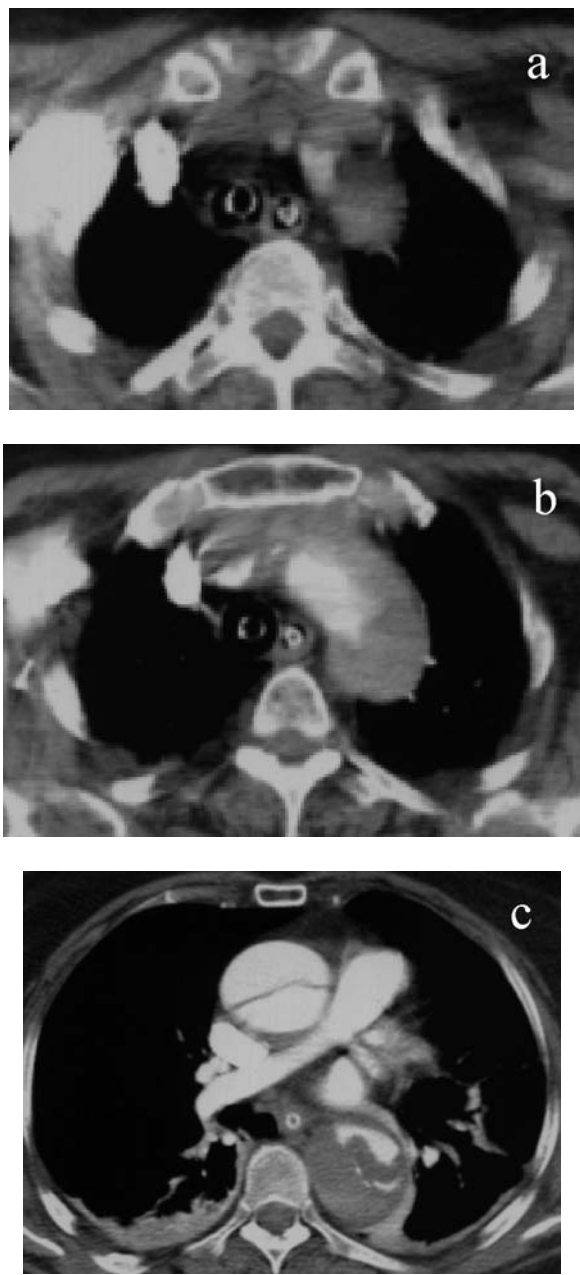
68-year-old patient affected by acute type A aortic dissection presenting with both carotid and femoral pulses absent. CT scan showing absence of blood perfusion in the supra-aortic trunks (panels a, b), and descending aorta largely interested by thrombosed false lumen (panel c).
